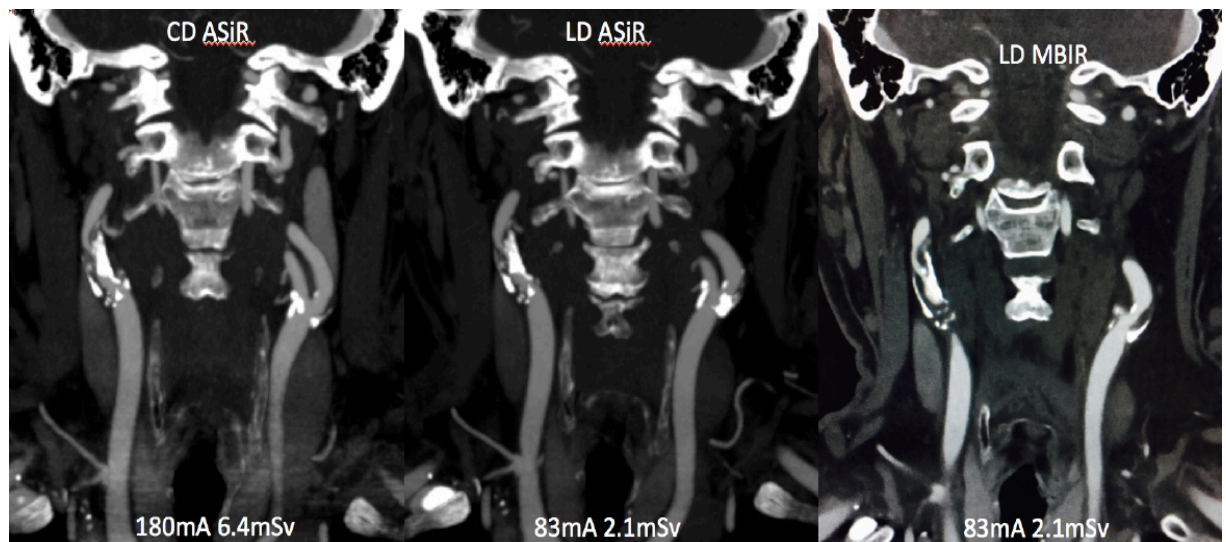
Coronal reconstructions of a CT carotid angiogram performed in a 62 year-old male patient with 85% stenosis of the proximal right internal carotid artery. The low-dose images reconstructed with MBIR and 40% ASIR have a similar diagnostic image quality to the conventional dose image (CD ASIR). The tube current (mA) and effective dose of each study are also shown.
